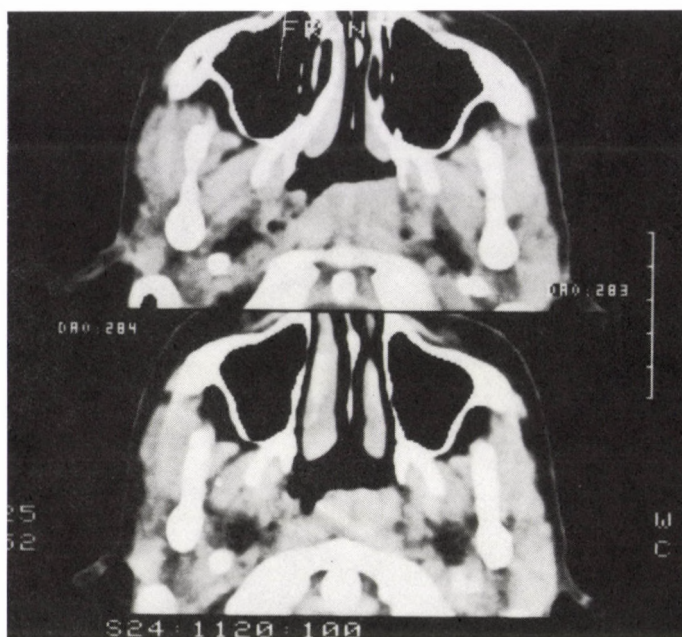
CT scan shows tumour of the nasopharynx as asymmetry on the left side of the posterior wall
